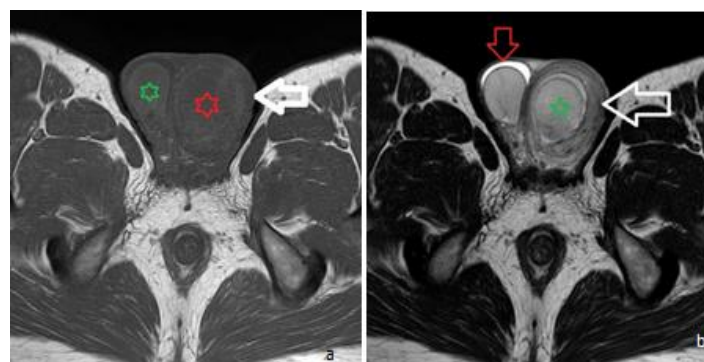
MRI scrotum axial section. (a) T1W shows normal hypo intensity of both the testes. Rt testis is normal in size (green star) as compared to enlarged left testis (red star). The overlying skin is thickened (white arrow). (b) T2WI shows normal intensity with slight increase in size of the left testis (green star). There is minimal free fluid in right scrotal sac shown as hyper intense crescent (inverted red arrow). Left scrotal skin and wrapping is thickened (white arrow).
